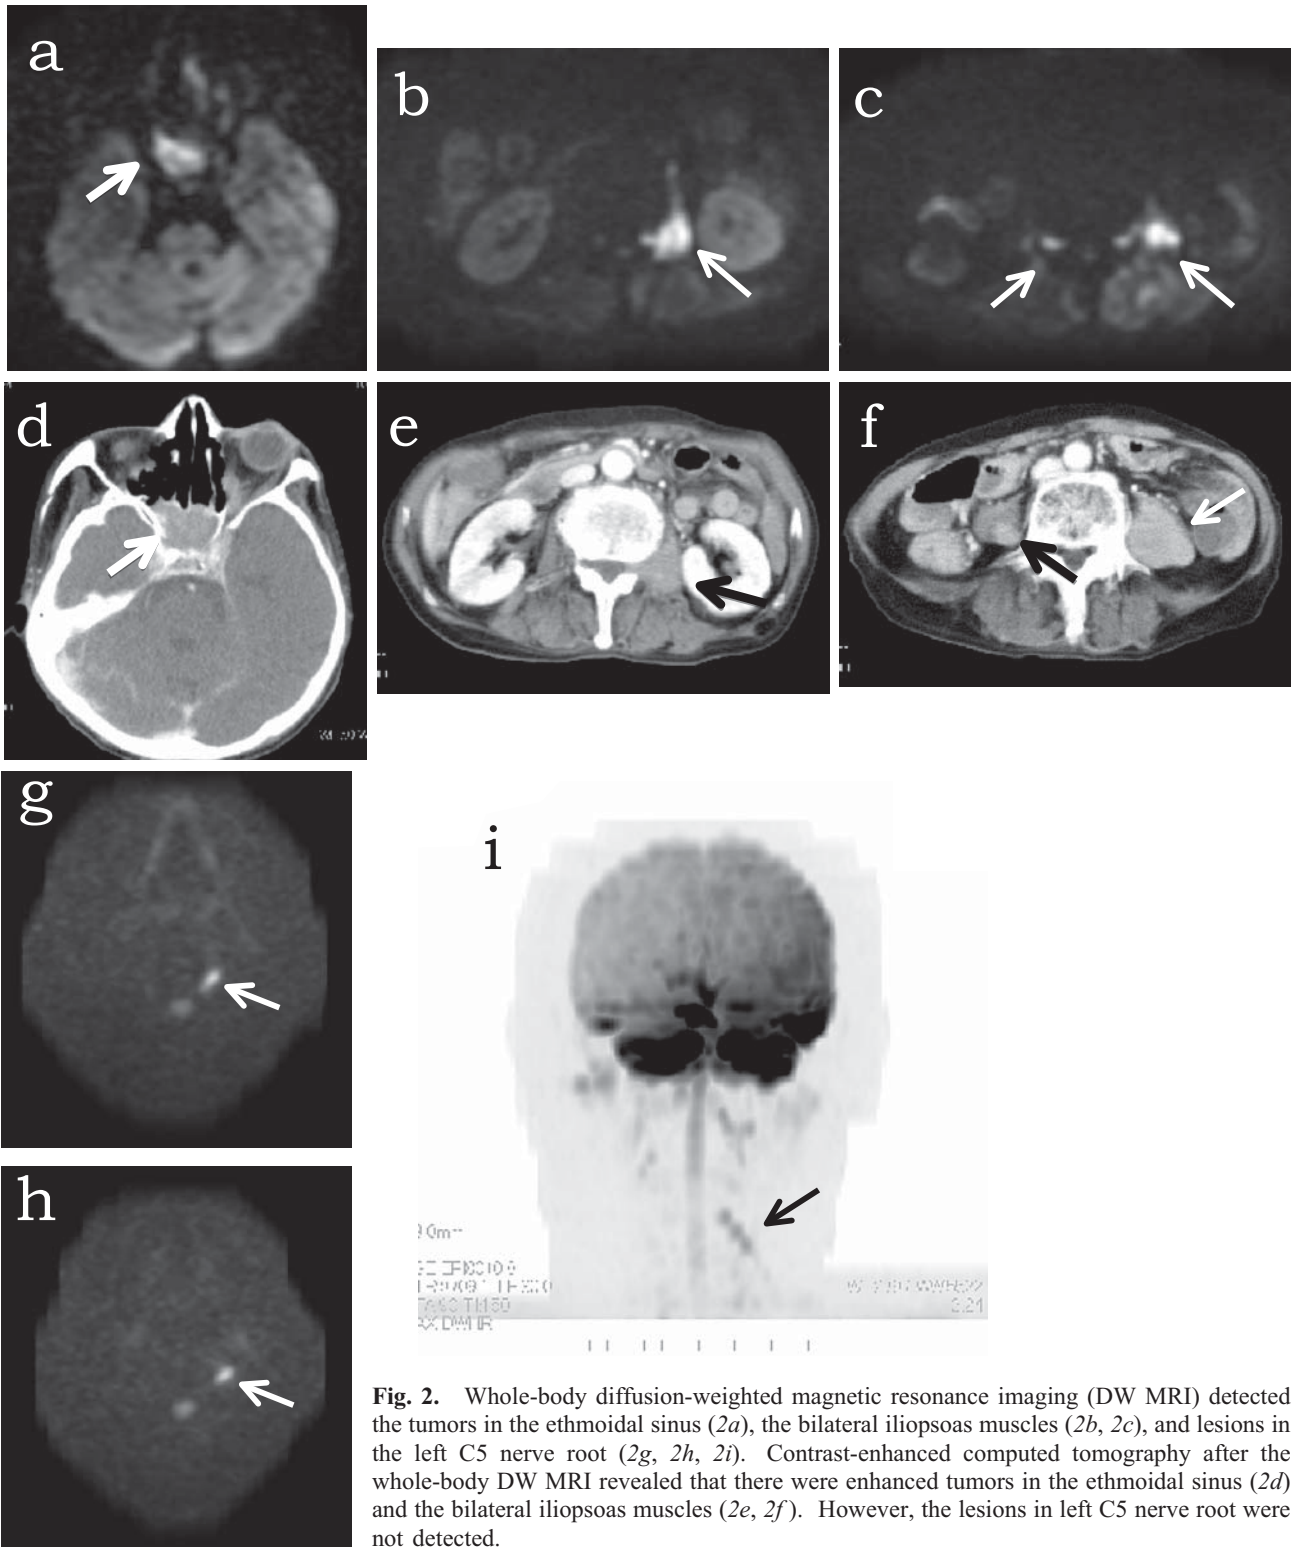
Whole-body diffusion-weighted magnetic resonance imaging (DW MRI) detected the tumors in the ethmoidal sinus (2a), the bilateral iliopsoas muscles (2b, 2c), and lesions in the left C5 nerve root (2g, 2h, 2i). Contrast-enhanced computed tomography after the whole-body DW MRI revealed that there were enhanced tumors in the ethmoidal sinus (2d) and the bilateral iliopsoas muscles (2e, 2f). However, the lesions in left C5 nerve root were not detected.
